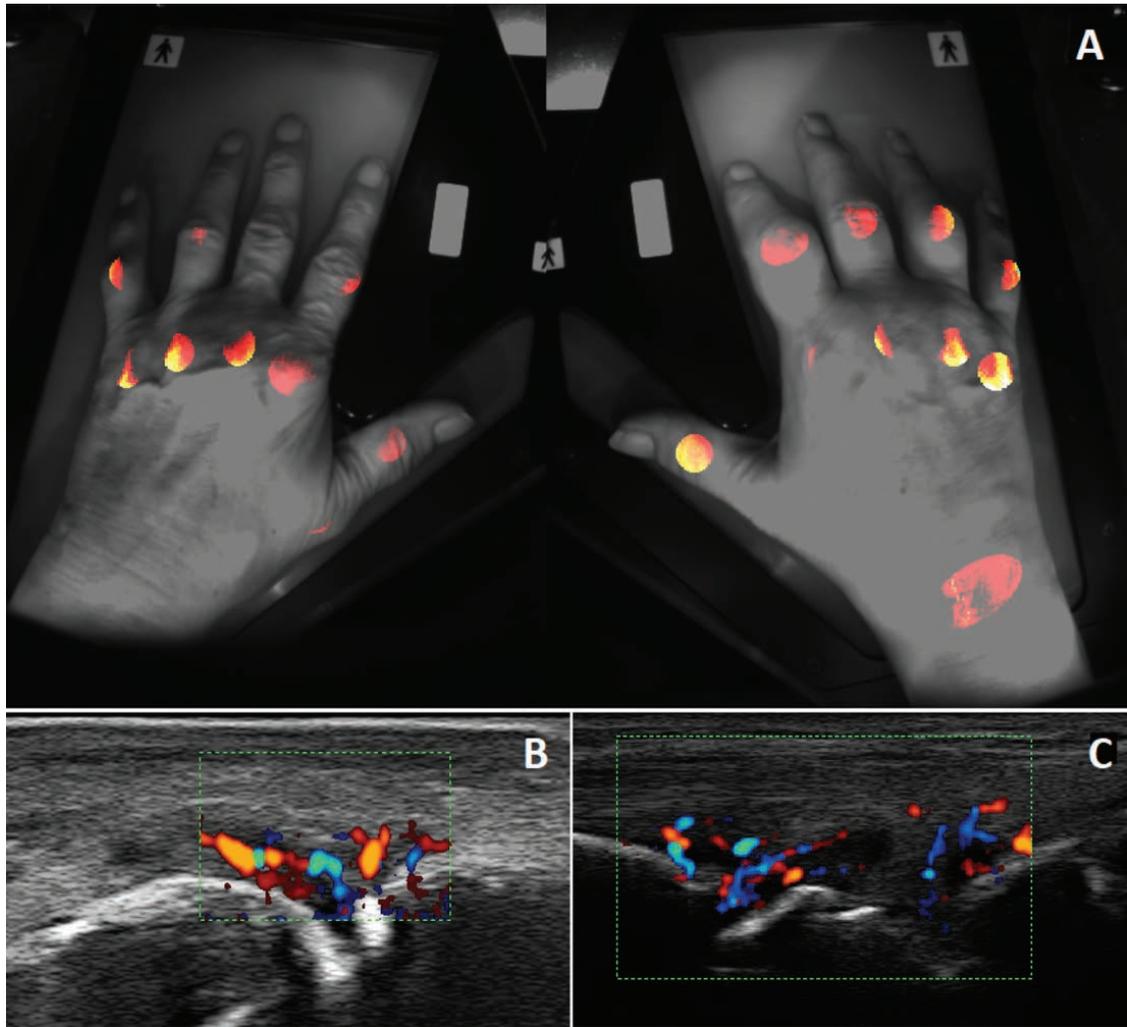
Assessment of inflammation by optical spectral transmission (OST) and ultrasound (US) in the wrists and finger joints of a female patient with rheumatoid arthritis (high disease activity). A. Result of the OST measurement. B, C. Power Doppler/greyscale US examination of the left MCP IV and right midcarpal joint, respectively (longitudinal views): joint effusions, synovial hypertrophy, and increased vascularity. MCP: metacarpophalangeal.
